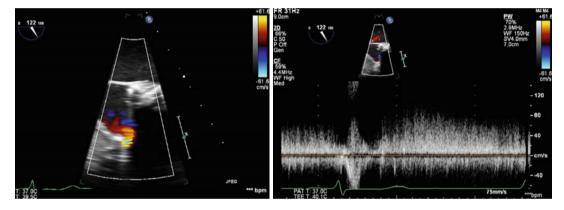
2D TEE color Doppler, long-axis view, status post myectomy, tissue AV and MV replacement, coronary flow seen drained to LVOT due to myectomy (*arrow*)
